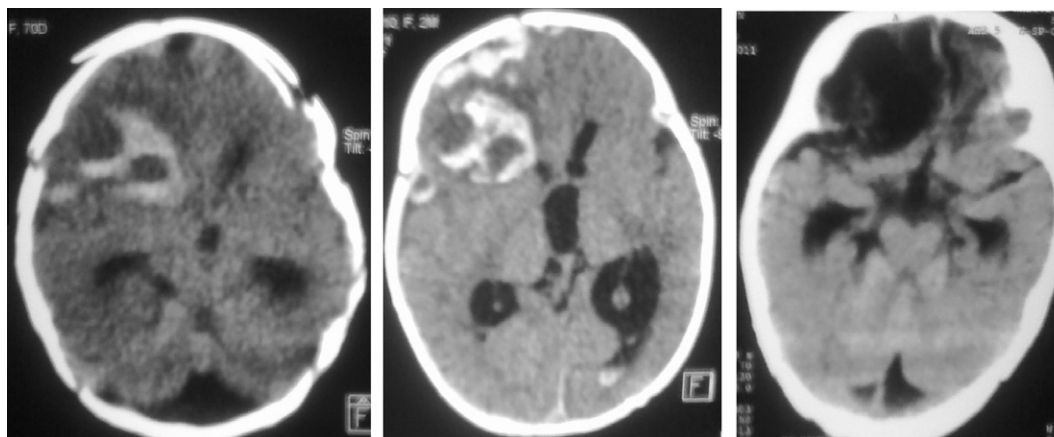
CT scan (axial view) showing post-traumatic right frontal ICH in a 2 months female child. Follow-up CT scan (axial view) three months after a conservative management showing resolution of ICH.
